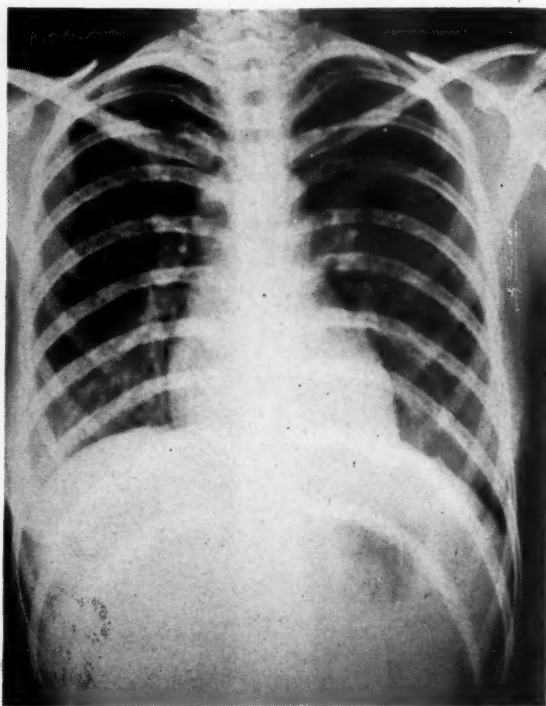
X-ray of chest ninety-six hours post partum.
